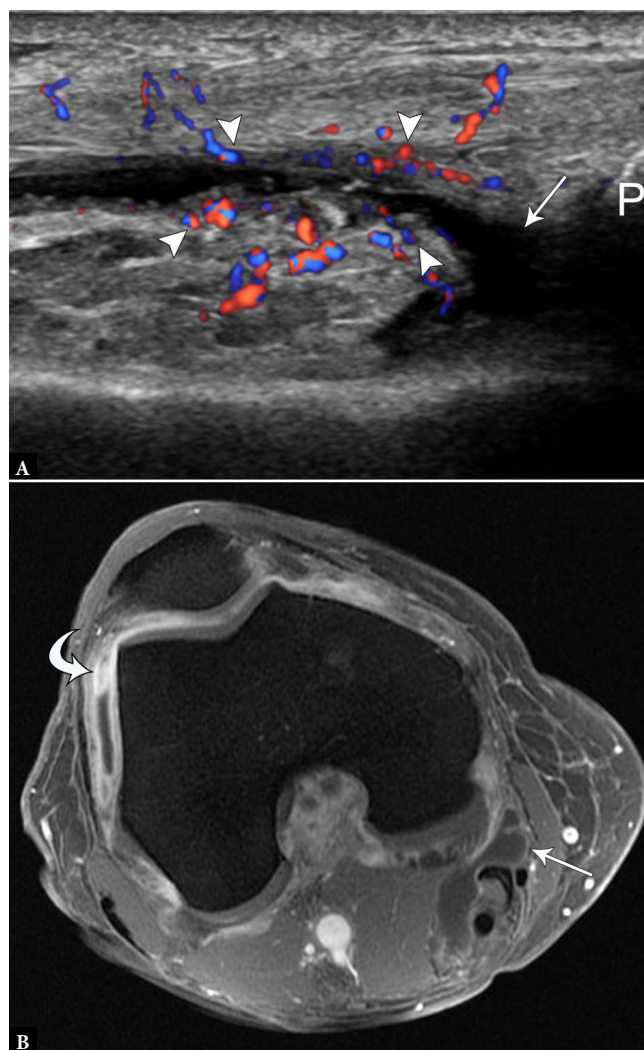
57-year-old female with osteoarthritis and synovitis. A. Longitudinal color Doppler US image superior to the patella (P) demonstrates small suprapatellar joint effusion (arrow) with hyperemic, thickened peripheral synovium (arrowheads). B. Post-contrast axial spoiled gradient echo MR image of the knee shows thickened and enhancing synovium, most prominent in the lateral gutter (curved arrow), compared to normal synovial enhancement of a Baker's cyst (arrow). P – patella
